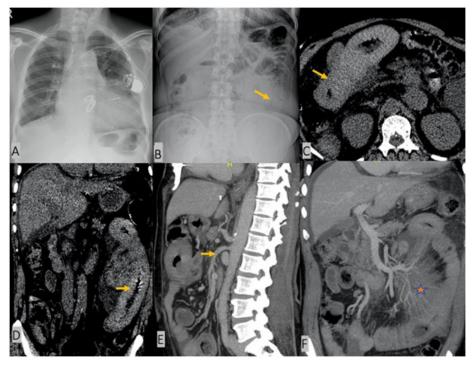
Plain radiograph of chest
